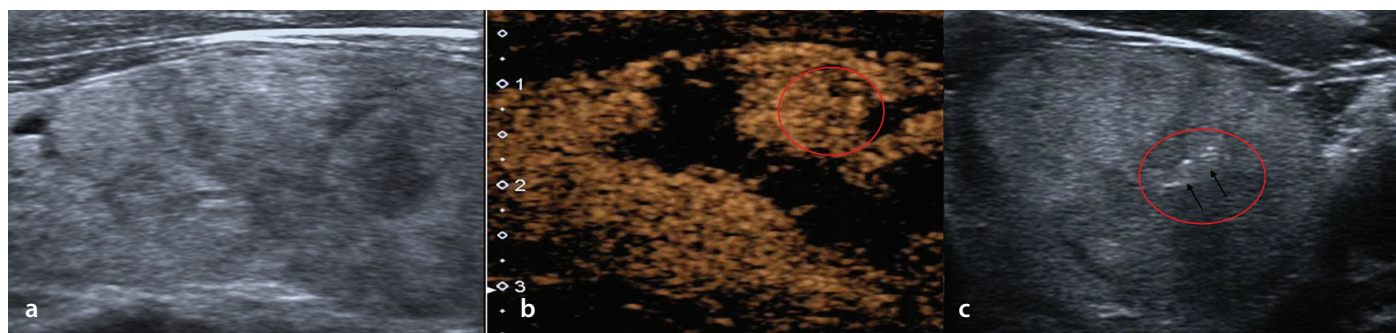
Images in a 39-year-old male patient with a solitary left-sided thyroid nodule classified with conventional ultrasound (US) as category TR4a and classified as Bethesda II following cytopathologic examination. Repeat US in the following 7 years showed no further change and no further intervention was necessary. (a) Longitudinal view of the left thyroid lobe displays an iso-echo, well-defined solid nodule. (b) Longitudinal contrast-enhanced US image shows the nodule is predominantly iso-enhanced with cystic areas, which were invisible with conventional US (red circle). (c) Transverse views of the needle area without cystic change were selected for cytology sampling (black arrows).
